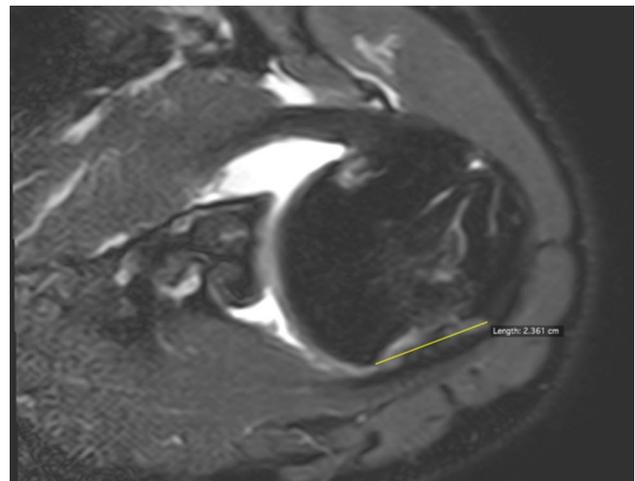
Estimation of the width of a typical Hill-Sachs lesion on T2-weighted fat-saturated MRI arthrogram axial sequence (23 mm in this example)
